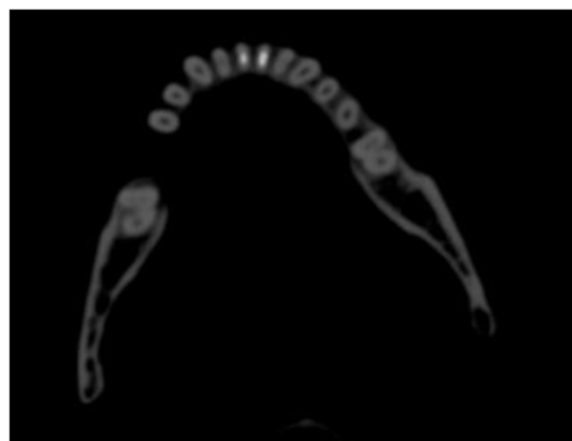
(a) PMCT axial section of upper teeth demonstrating multiple missing teeth. The pattern of missing teeth, as well as the positions and dispositions of remaining teeth, are concordant with the antemortem CT images.
